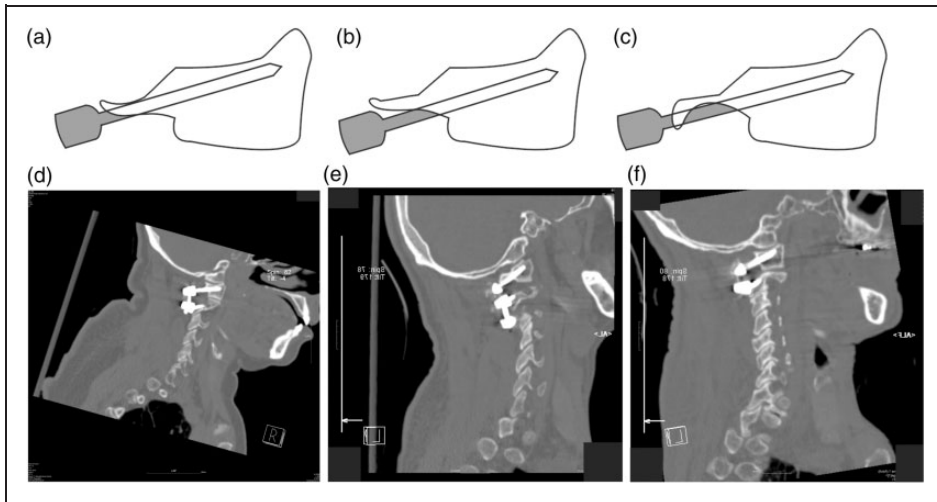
Pedicle height measurements identify three potential regions for atlas pedicle screw placement. Depending on the preoperative height measurements, atlas pedicle screws were placed under the posterior arch (type I) (A), at the junction of the pedicle lateral mass (type II) (B), or spanning the vertebral artery groove and penetrating into the pedicle lateral mass using an 'in-out-in' technique (type III) (C). The postoperative computed tomography scans corresponding to the three types of screw placement, (D–F), respectively.
